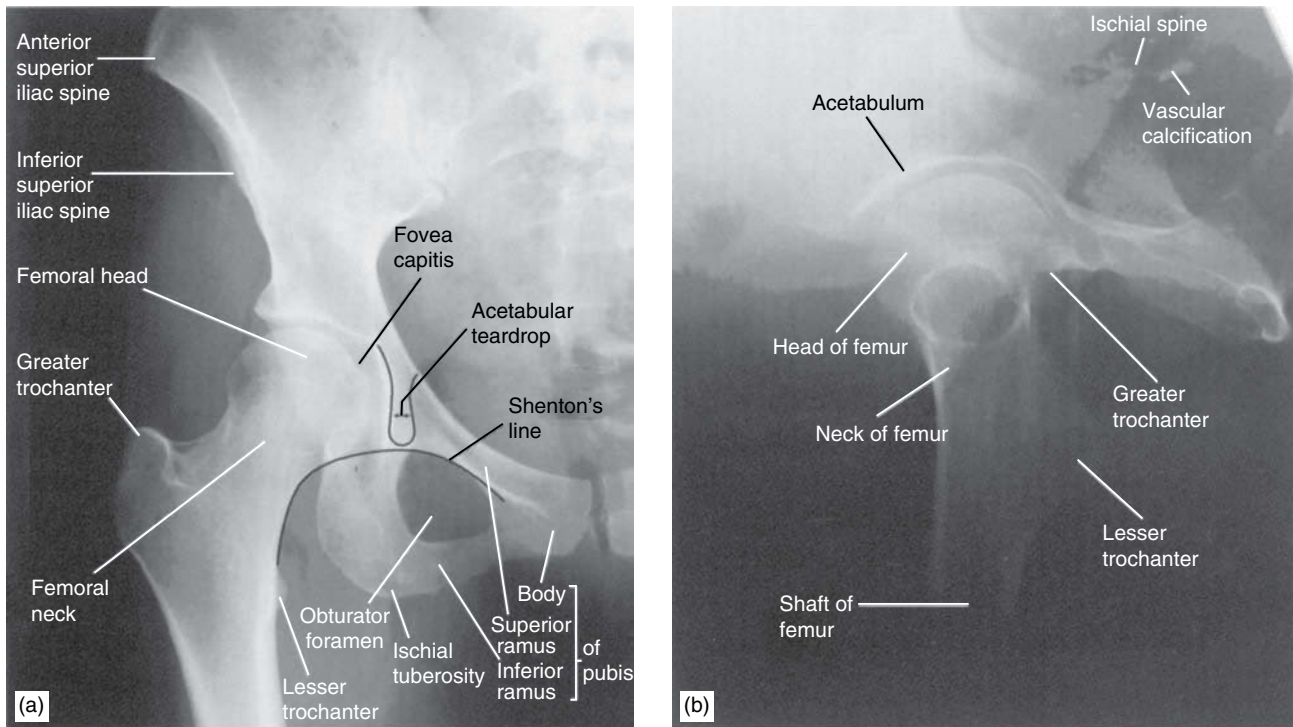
(a) Anteroposterior and (b) lateral radiographs of the hip. Reproduced from Butler P, Mitchell AWM, Ellis H, *Applied Radiological Anatomy*, Cambridge University Press, Cambridge, 1997.
